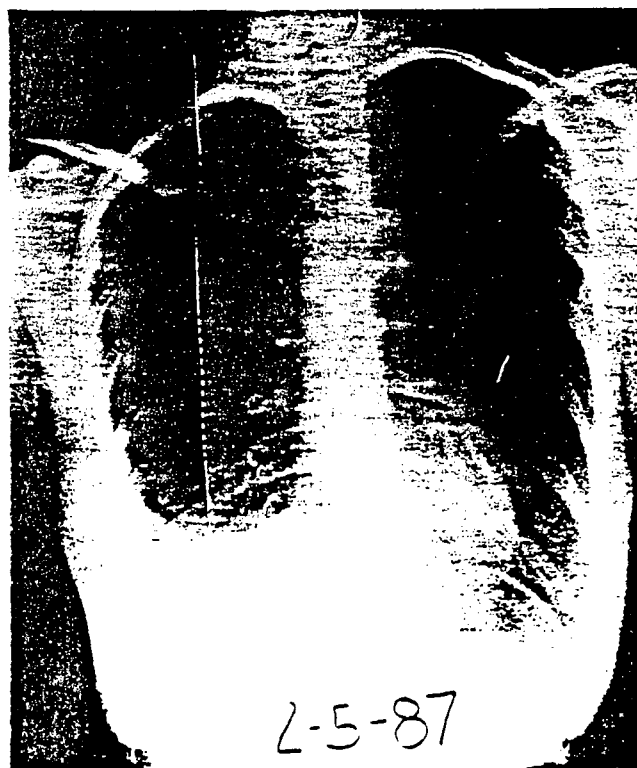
Chest roentgenogram demonstrating scoliosis and right pleural effusion.
